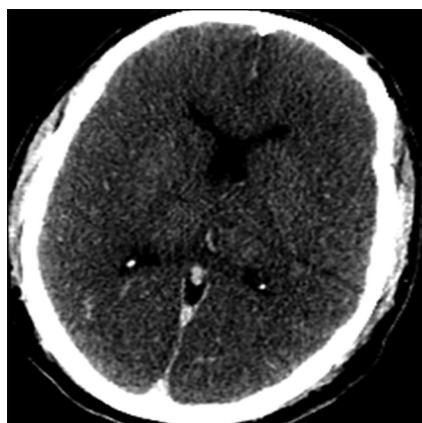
Visualization of the basal ganglia. Axial CT using narrow window and level (50W 35 L) allows for visualization of both the basal ganglia and thalami.
